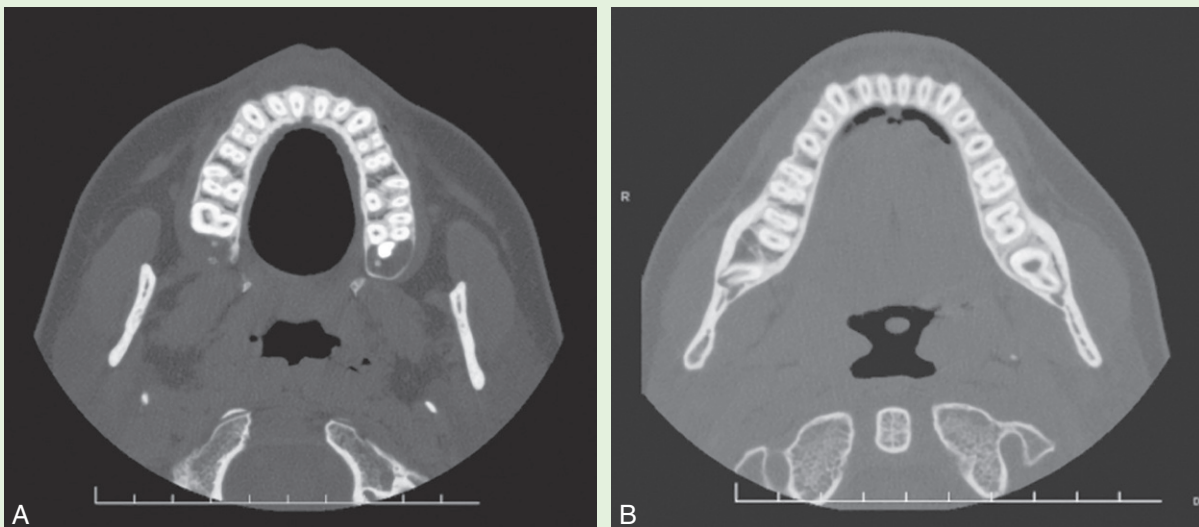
Horizontal computed tomographic scans of KP's upper arch (A) and lower arch (B) taken after 2 years, 6 months in retention.
